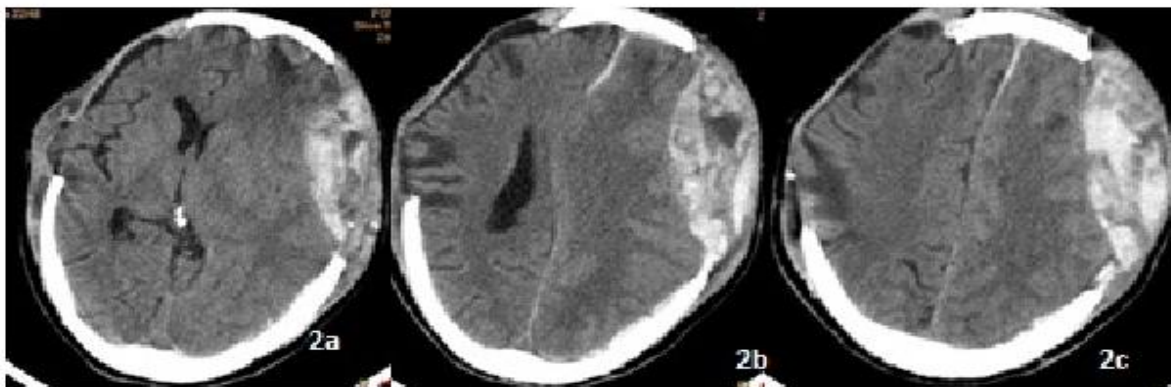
(a, b, c)- Axial CT scan of brain with left frontal extradural hematoma with mass effect, midline shift with bilateral calvarial defects.
